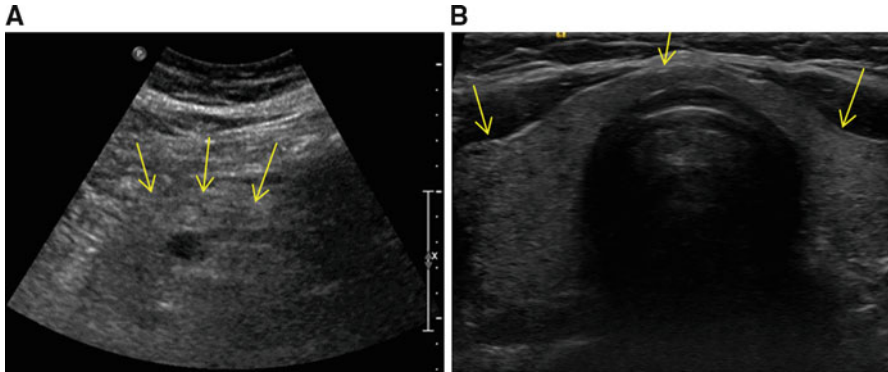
Ultrasound images using a low-frequency transducer and a high-frequency transducer. (a) Ultrasound image of the pancreas using a 5.5 MHz curvilinear transducer. Pancreas outlined by arrows. (b) Ultrasound of the thyroid using an 11 MHz linear transducer. Thyroid outlined by arrows*
